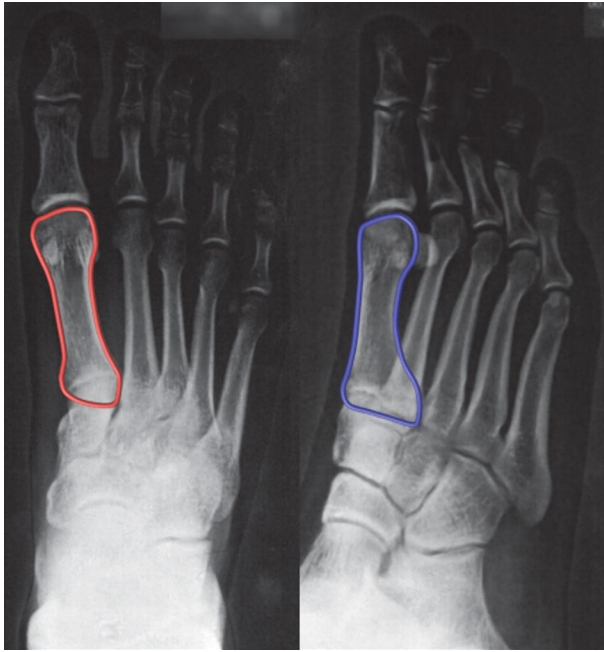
A new biplanar X-ray with the two contours of the first metatarsal highlighted.
